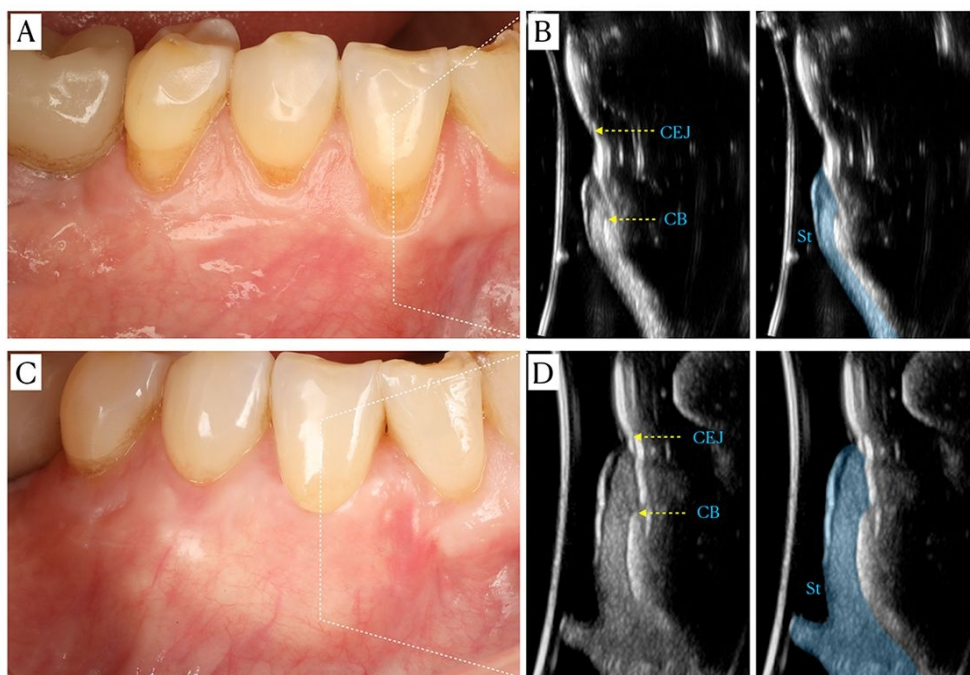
Clinical and ultrasonographic outcomes of the case 2. A) Baseline. B) Ultrasonographic scan of the midfacial aspect of tooth #27, where the crestal bone "CB", the cemento-enamel junction ("CEJ") and the soft tissue ("St") are pointed out. Note that the distance between the CEJ and the CB appeared to be reduced from baseline to 18 months.
